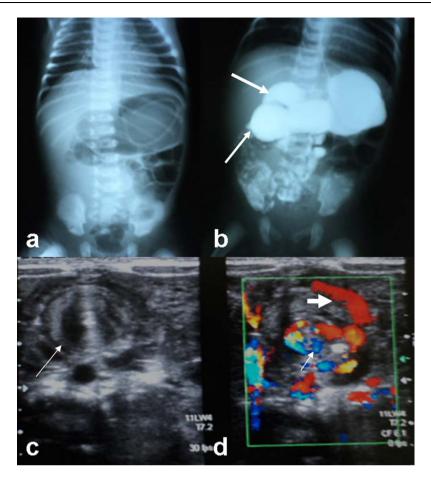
A 8 days neonate with persistent vomiting (a) plain X-ray film with Ryle's tube showing distended stomach and duodenum by gases. (b) Contrast study revealing of dilated duodenum and proximal jejunum (long thick arrows). (c) US image of volvulus mass (Long thin arrow). (d) Color Doppler image showing the winding SMV (Short thick arrow) with the central site of SMA (short thin arrow).
